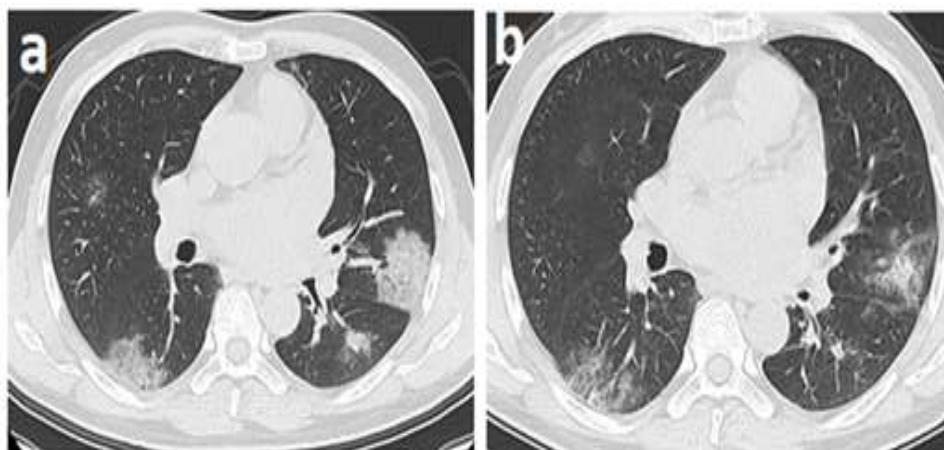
(a and b) axial chest CT images (lung window)
